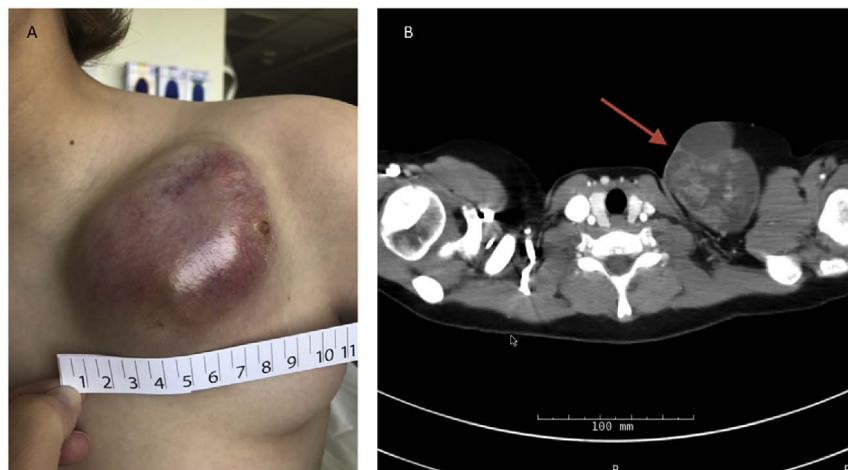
A: Initial presentation of the patient's chest wall mass. A small, 1 cm punctate lesion can be noted on the left border of the lesion where the patient underwent biopsy. B: The patient's mass as seen on CT, demonstrating a large ( $7.5 \times 7.0 \times 5.5$  cm) well-defined left supraclavicular mass containing mixed cystic, enhancing solid and small fatty components. The mass abuts the superior margin of the pectoralis muscle, however there is no gross invasion of adjacent soft tissue structures or mass effect. Based on these features, the mass was initially thought to represent a malignant lesion such as a soft tissue sarcoma.
